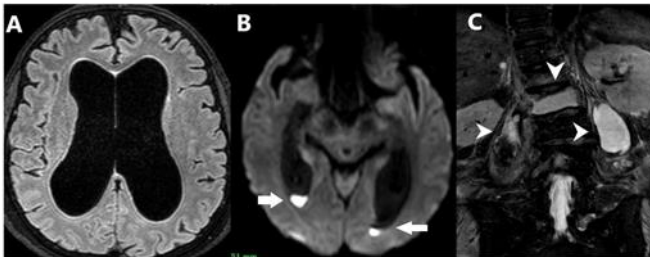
A-MRI Axial T2 image showing communicating hydrocephalus B- Diffusion-weighted images showing collection in ventricles-ventriculitis (arrows) C- Coronal STIR sequence showing bilateral psoas and intra-osseus collections(arrowheads)
